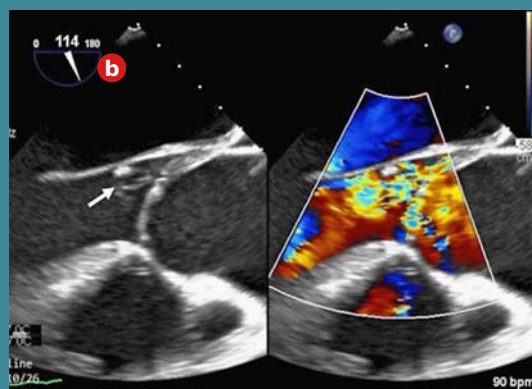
Transoesophageal echocardiography (TEE) - dilated aortic annulus, bicuspid aortic valve, fusion of RCC and LCC cusps and raphe at 2 o'clock (a); mobile mass visible in LVOT with an echostructure similar to that of the cusp, possible ruptured cusp aneurysm with attached vegetation (arrow) and severe aortic regurgitation with eccentric jet (b); ruptured aneurysm of anterior mitral leaflet (x) and severe mitral regurgitation with a thick jet through the aneurysm (c).
